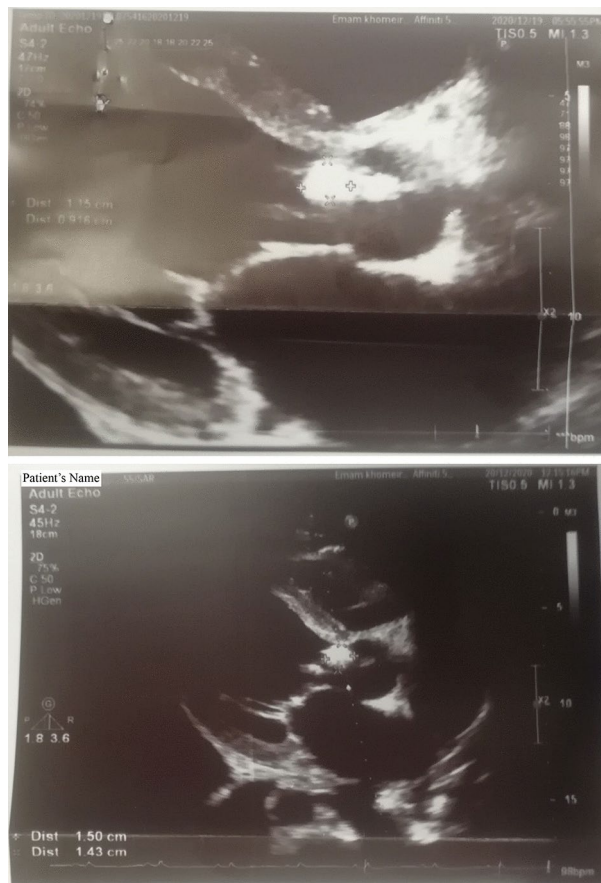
Echocardiogram of *Bartonella quintana* positive patient. The vegetative mobile mass on the aortic valve is indicated by “+” sign.
